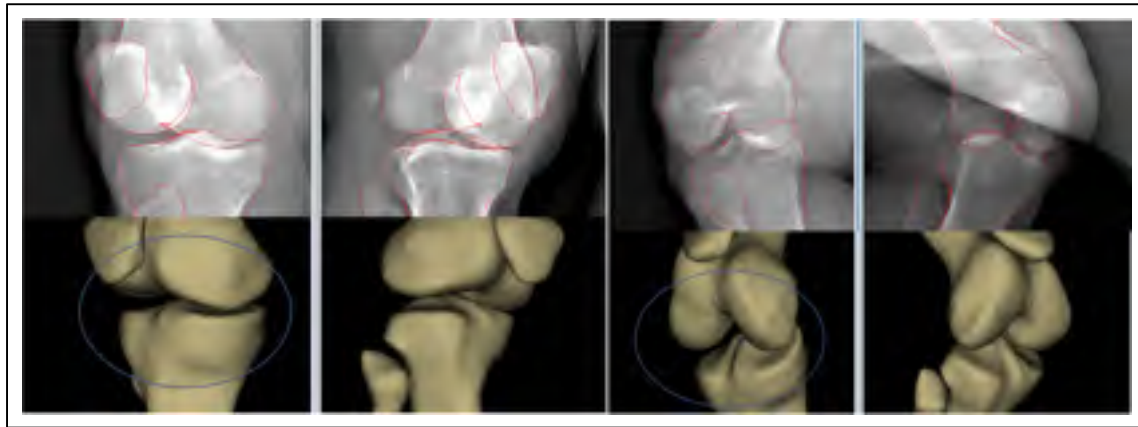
Tibiofemoral joint imaged from 2 different angles using EOS® biplane images. The tibial plateau in the left pair of images is viewed from a tight angle where the anterior and posterior edges in the X-rays are superimposed. The right pair of images is the joint images at a different posture where the edges are not superimposed.
